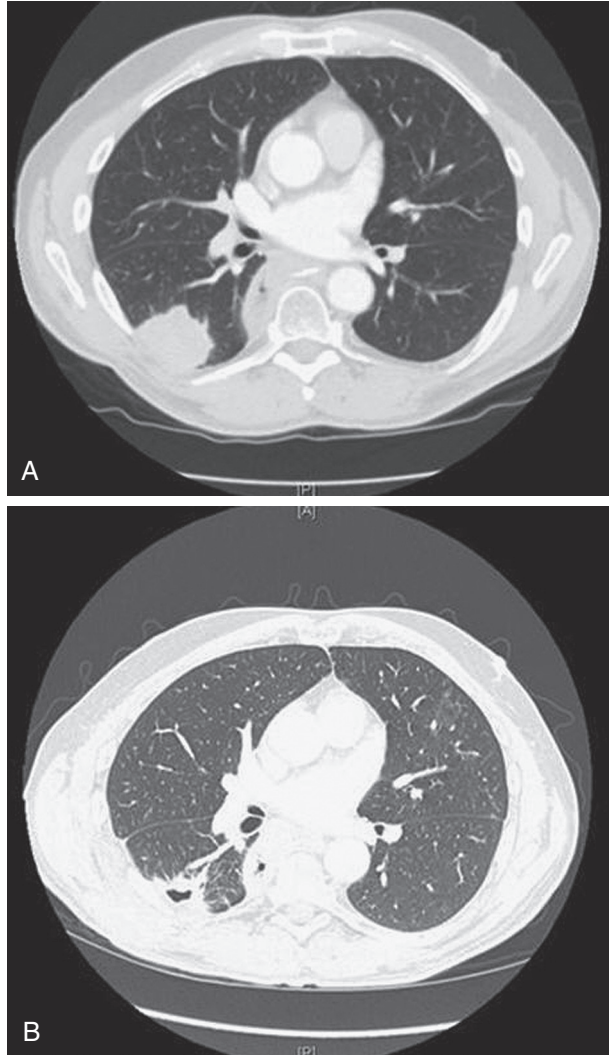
■ Radiographic evidence of tumor ablation: A, Before ablation. B, Three months after ablation; note central cavitation and overall decrease in size.
